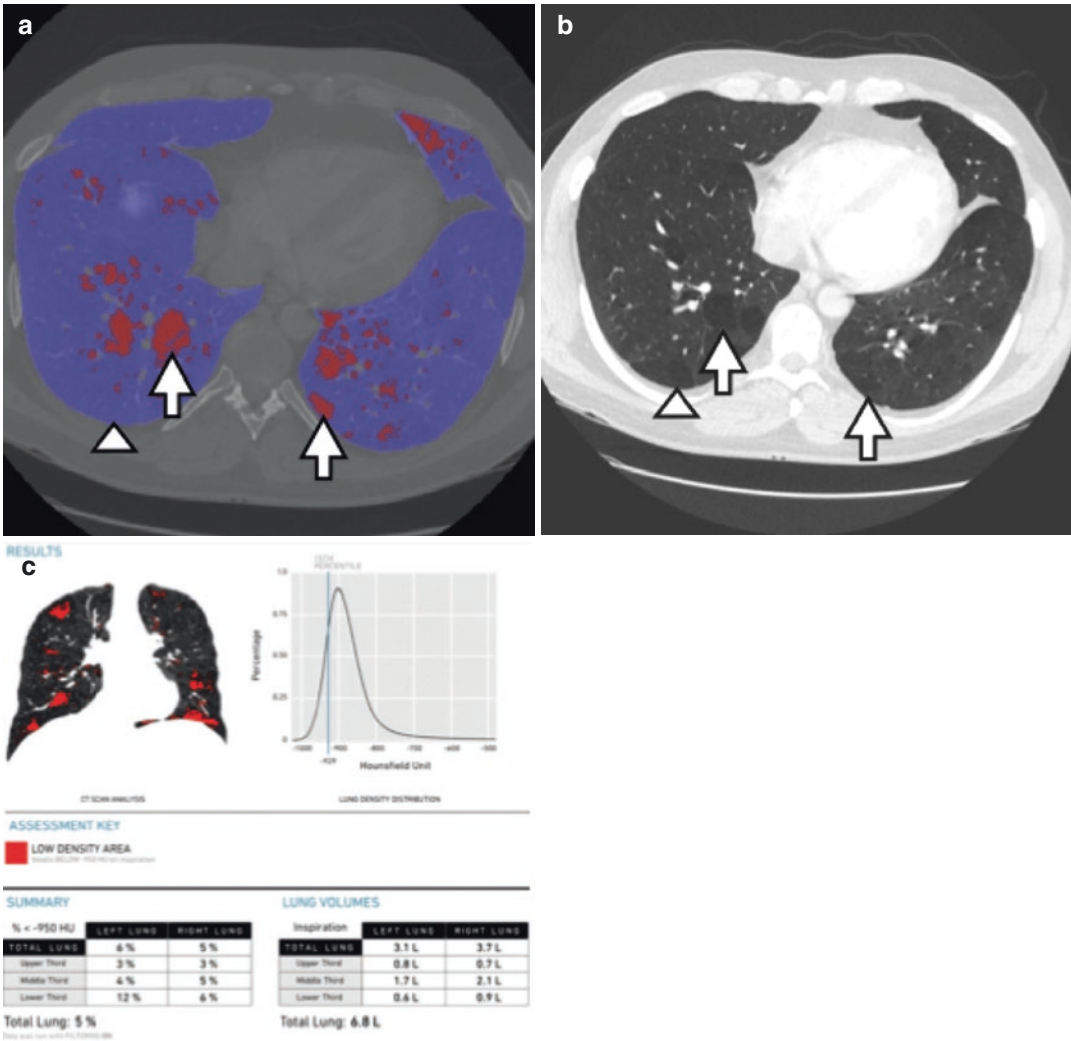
Lung density. Lung density assessment was performed in a 44-year-old male patient with history of bronchopulmonary dysplasia as a child that has been experiencing progressive shortness of breath. Axial CT image of the lung bases displayed on lung window setting demonstrates nonuniform attenuation of the lung parenchyma; the comparative low-density regions are denoted with an arrow (a). These low-density regions of concern
